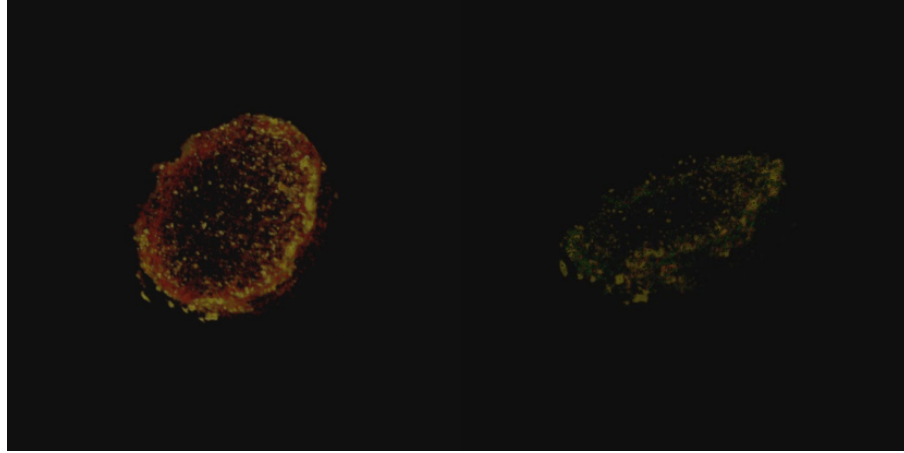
Summary of mineralized tissue (hard ECM) deposited in Day 16 cultured constructs reconstructed following  $\mu$ CT. Mineralized tissue = Red, PLLA fibers = Gray, Cells outside of ECM = Green, Soft tissue = Yellow
